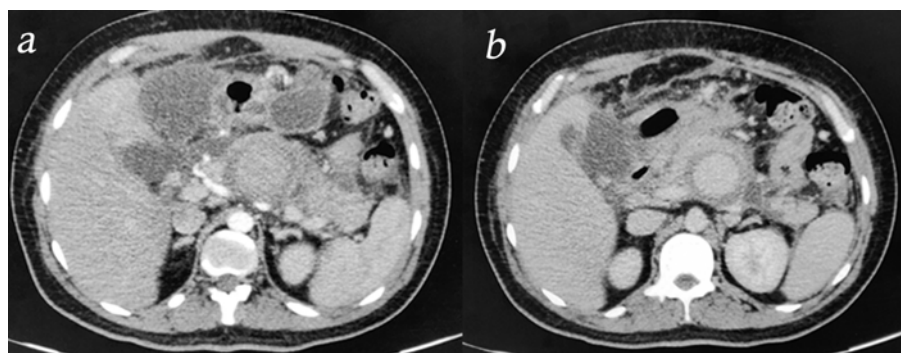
Body of Pancreas (a) Arterial phase CT with a well defined lesion just behind pancreas (b) Venous phase CT of the same lesion with enhancement
